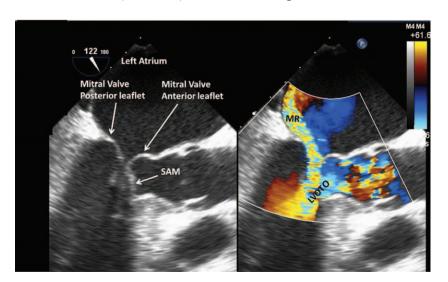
Systolic anterior motion (SAM) of the mitral valve without and with color Doppler. Transesophageal echocardiography (TEE) image. LVOT = left ventricular outflow tract.
